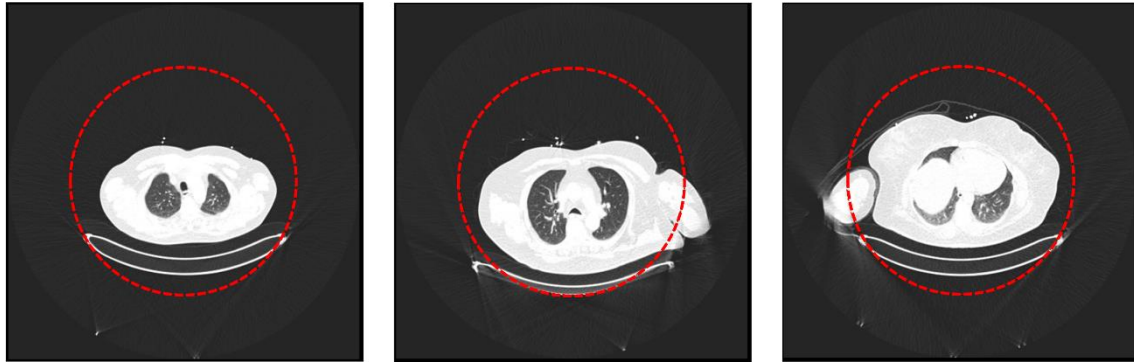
Example CT images showing cases without truncation (left) (Male BMI 28.3 kg/m², arms up) and two examples with truncation (center: Female BMI of 39.1 kg/m² and left arm down; right: Female BMI of 33.7 kg/m² and right arm down)
